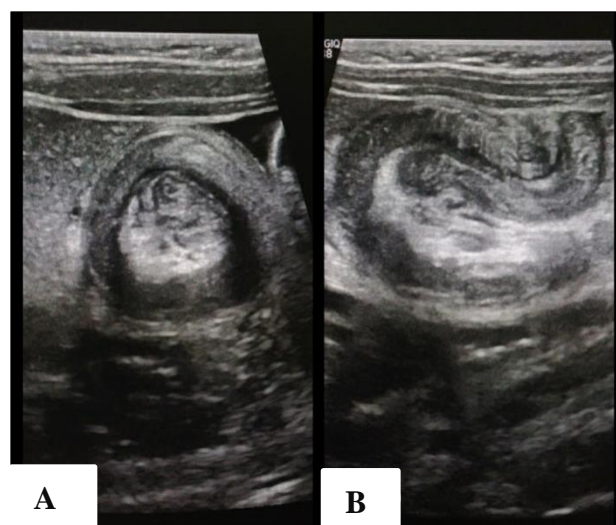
Transverse (A) and longitudinal (B) sonographic images in an 8 month old patient with ileo-colic intussusception showing the characteristic Target and pseudokidney signs, respectively.
